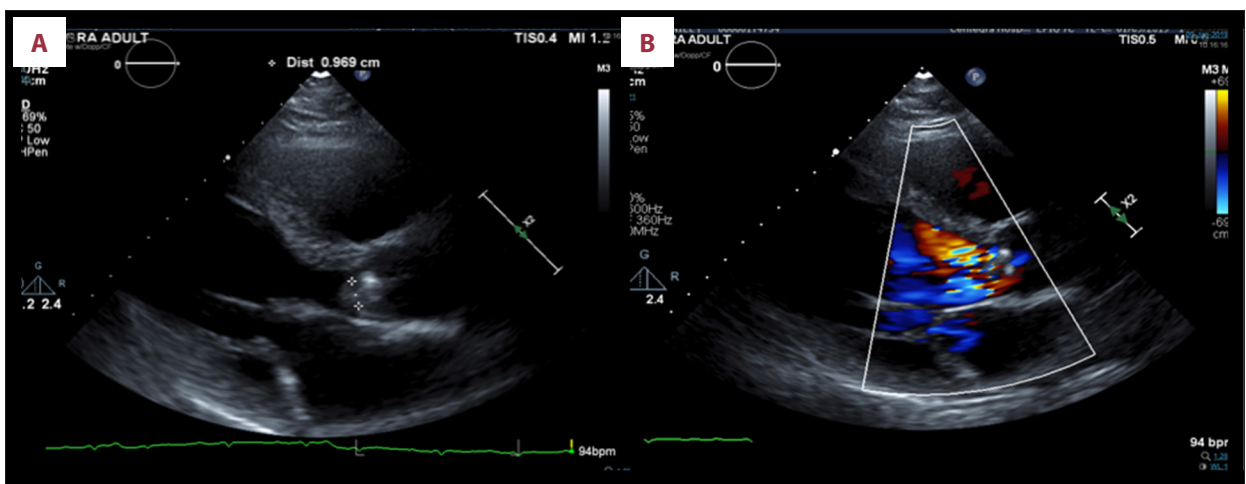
Paraseptal view on transesophageal echocardiography (TEE) demonstrating severe aortic regurgitation (A: mean regurgitant flow of 409 cm) with approximately 1 cm sized mobile aortic valve vegetation (B).
